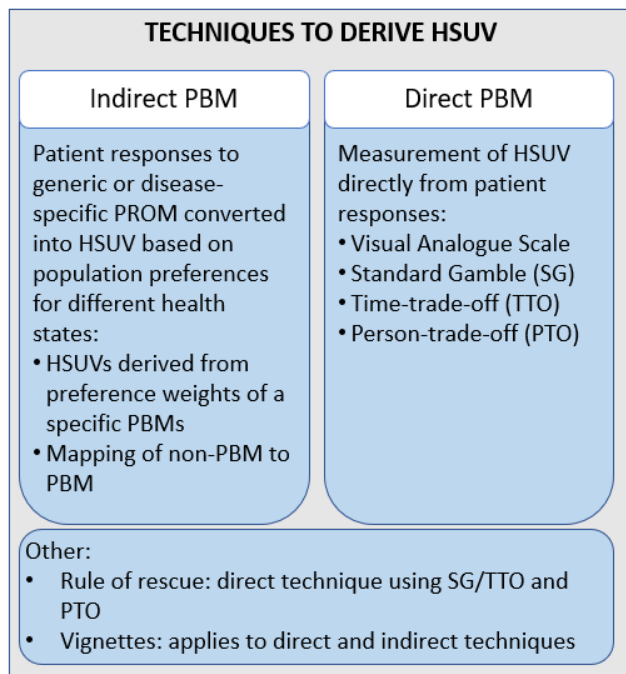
summarises the use of direct and indirect techniques to derive HSUVs. Indirect techniques are used to derive HSUVs from preference weights developed for disease-specific or generic PROMs (e.g. EQ-5D) using direct approaches, or through application of mapping algorithms relating non-PBMs to PBMs. Direct techniques measure HSUV directly from patient (or from the public using hypothetical descriptions) through various techniques, usually choice-based.
